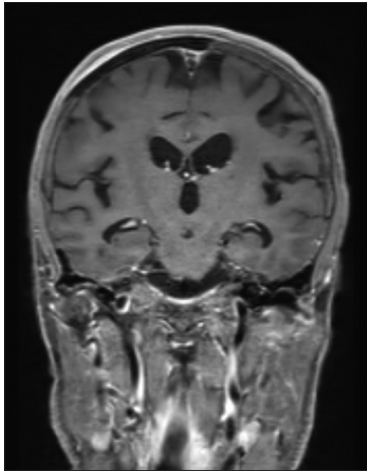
Coronal contrast enhanced magnetic resonance imaging section at the level of aqueduct in midbrain
